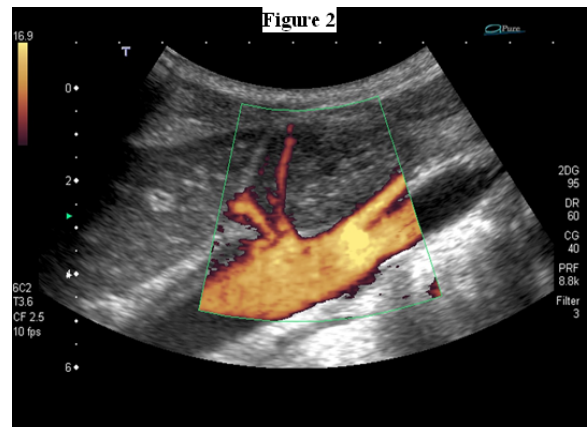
Power Doppler US demonstrated the celiac trunk passing through the mass and SMA is adjacent to inferior border of the tumor.
